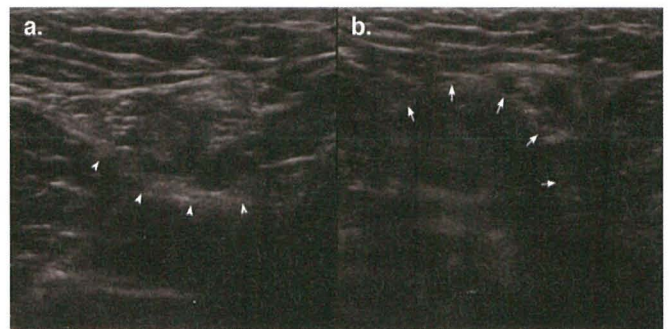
Ultrasound scan of an indirect inguinal hernia showing the inguinal canal at rest (a.) and during Valsalva manoeuvre. b. Note the expansion of the inguinal canal that occurs with increased intraabdominal pressure (arrows).
